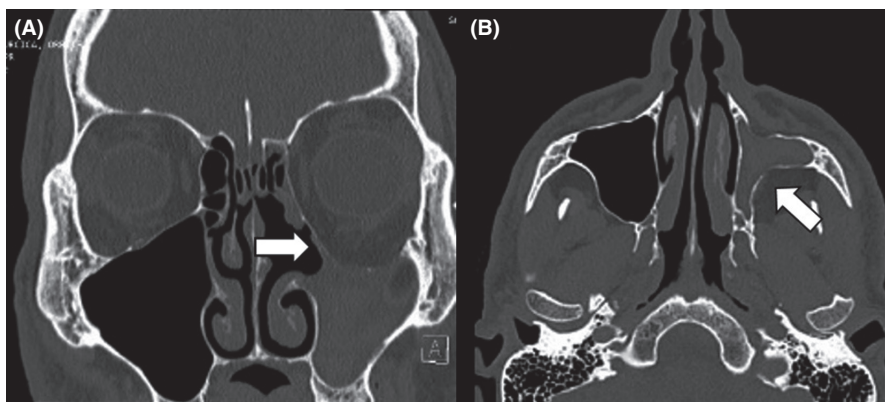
Coronal (A) CT scan showed opacification of the left maxillary sinus with collapsed orbital floor (*arrow*); an axial CT scan showed maxillary sinus hypoplasia (B) with collapsed bony walls (*arrow*)
